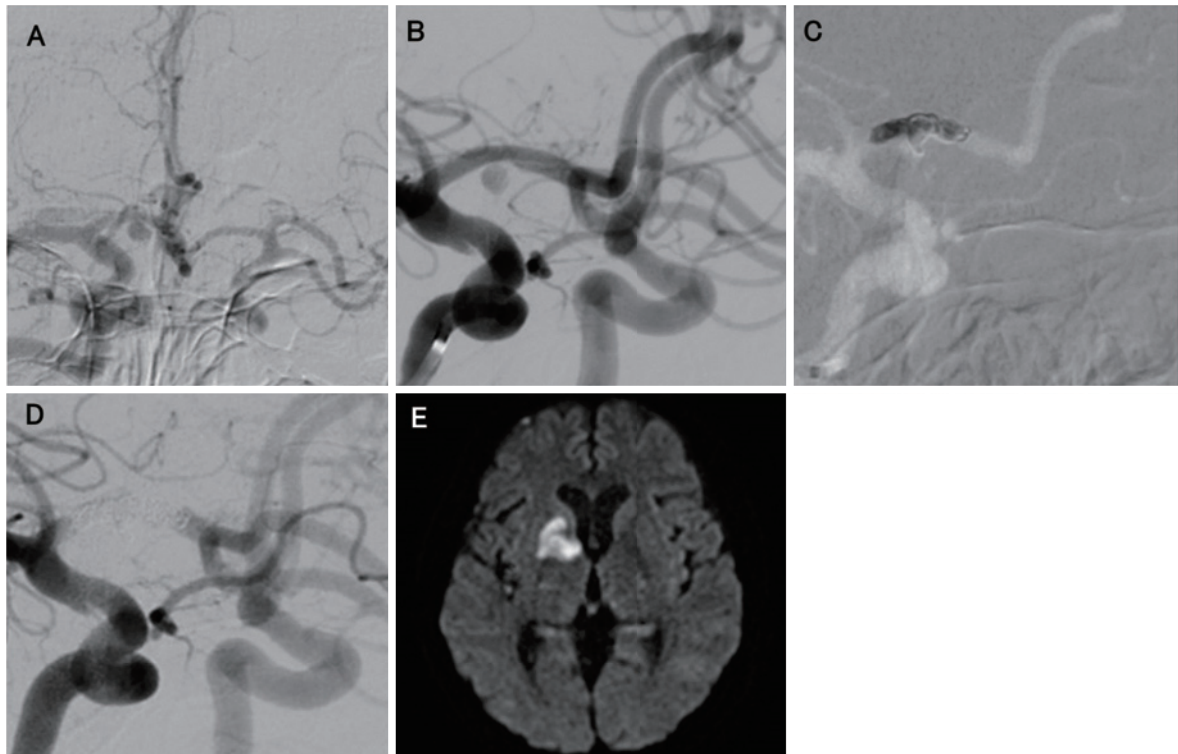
The Matas test showed sufficient collateral blood flow from the contralateral anterior cerebral artery (A). Bilateral internal carotid artery (ICA) angiography (B). No intraoperative aneurysmal rupture was observed during the internal trapping of the A1 segment (C). Bilateral ICA angiography after trapping showed complete obliteration of the dissected segment (D). Magnetic resonance imaging after trapping showed cerebral infarction in the territory of the A1 segment perforators (E).
